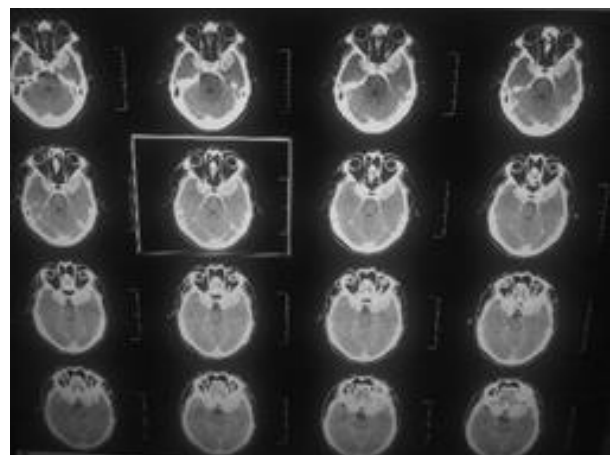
Preoperative CT Brain with contrast showing bilateral clinoidal lesion.
